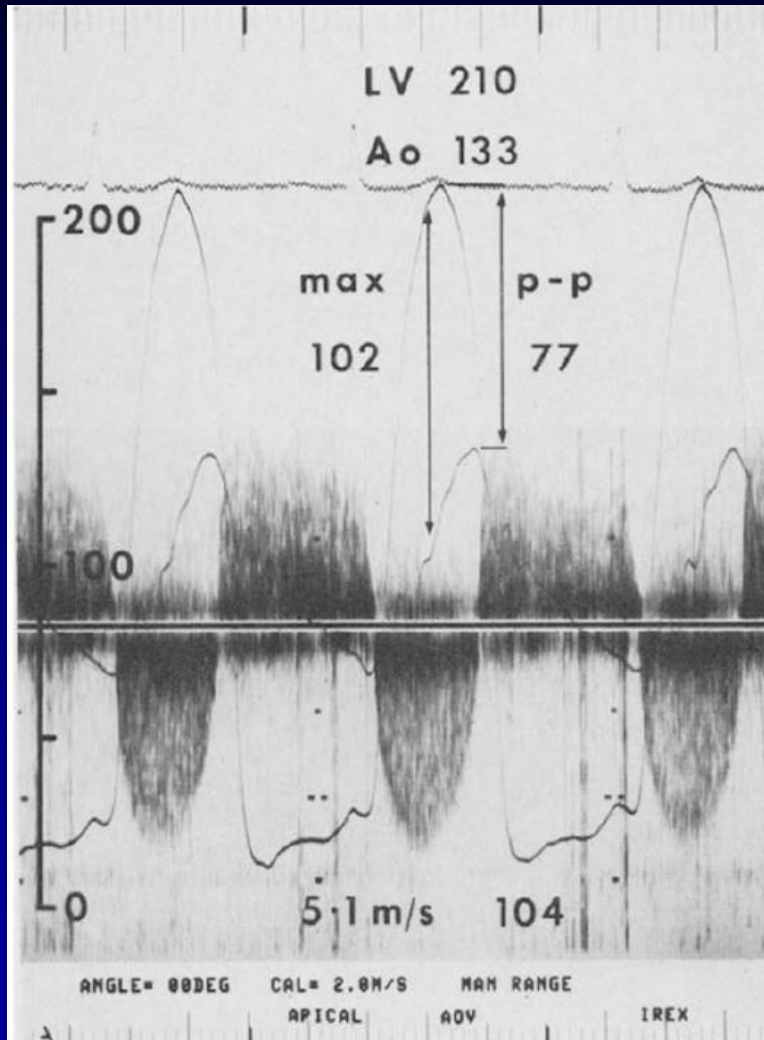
A, Simultaneous Doppler and dual catheter pressure recordings in a patient with severe valvular aortic stenosis. The maximal catheter gradient (max) of 102 mm Hg corresponded closely to the maximal instantaneous Doppler gradient of 104 mm Hg. The peak to peak catheter pressure gradient (p-p) was 77 mm Hg. Note that the peak left ventricular (LV) pressure and the peak aortic (Ao) pressures are nonsynchronous; therefore, the peak to peak catheter pressure gradient does not represent an instantaneous pressure gradient. B, Same patient. Instantaneous Doppler and catheter pressure gradients from the digitized Doppler spectral velocity envelope and simultaneous left ventricular and ascending aortic pressure waveforms of the second beat from A. The instantaneous catheter gradient (closed circles) is comparable with the Doppler-derived gradient (open circles). Note the slight phase delay related to the fluid-filled catheter system. The mean catheter gradient (area under the curve divided by gradient time) was 69 mm Hg and the mean Doppler-derived gradient was 74 mm Hg.
